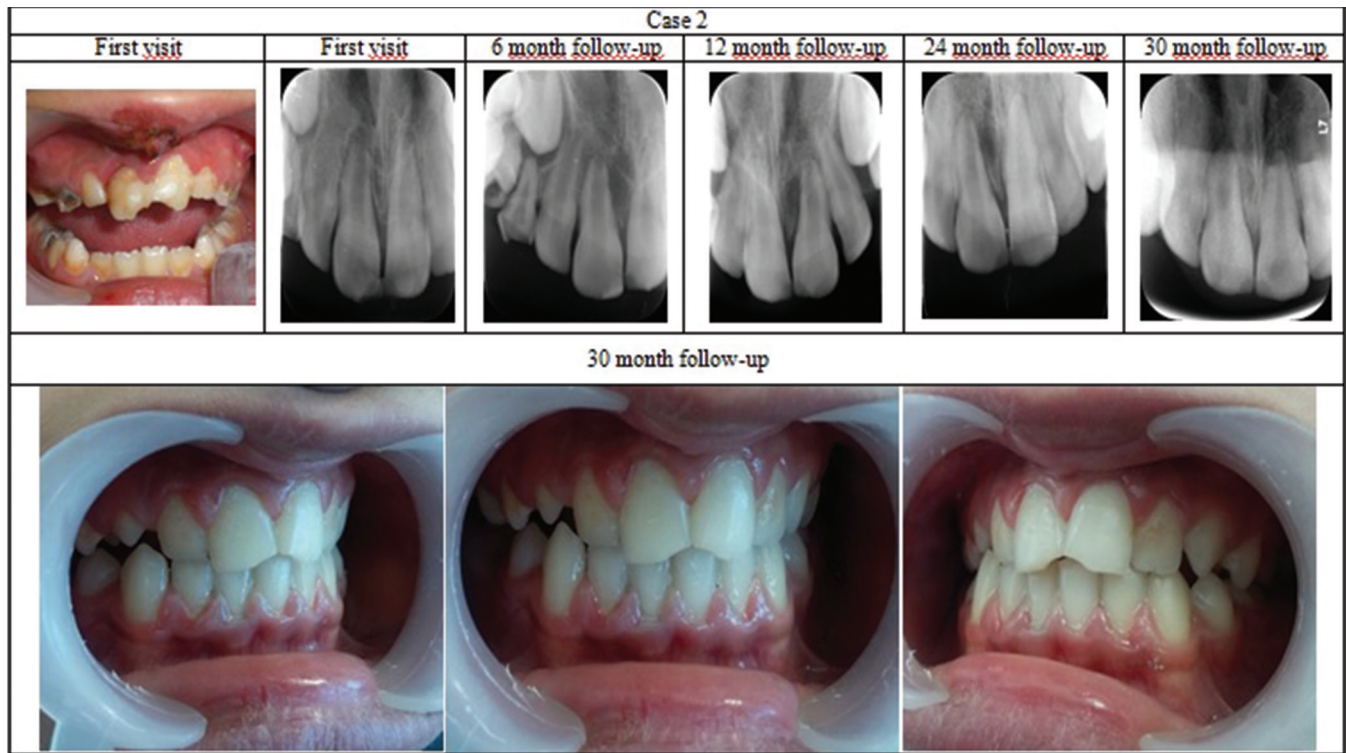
Radiographic and clinical records of case 2
